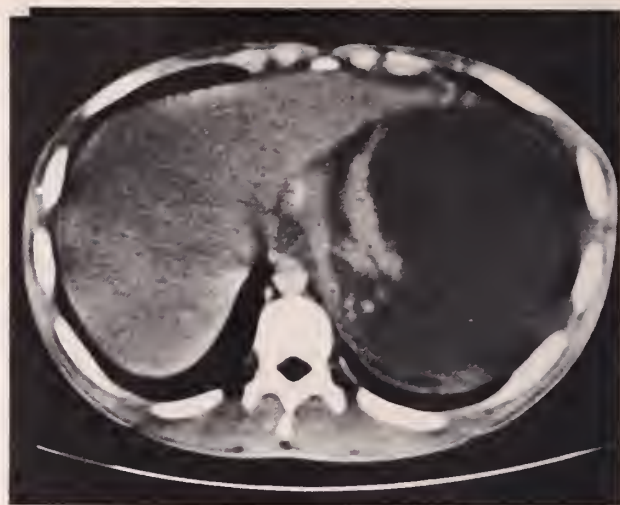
Abdominal CT scan demonstrating large cystic mass in left upper quadrant obliterating spleen and tail of pancreas.
